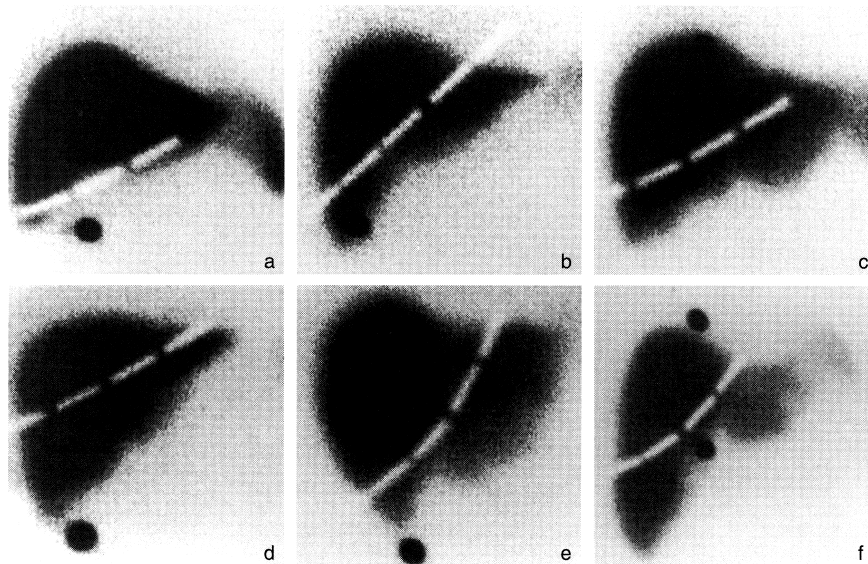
Radioisotope scans of the liver showing variability in organ shape. Note the costal margin markers as white broken lines and the other two dark point markers for research purposes; respiratory excursion blurs and expands the point markers—a limitation on the precision of any study done with reference to scintigraphic standards. Images a through d show variation in alignment with the costal margin; images e and f show, respectively, prominence of the left (caudate) and right (pyramidal) lobes.
